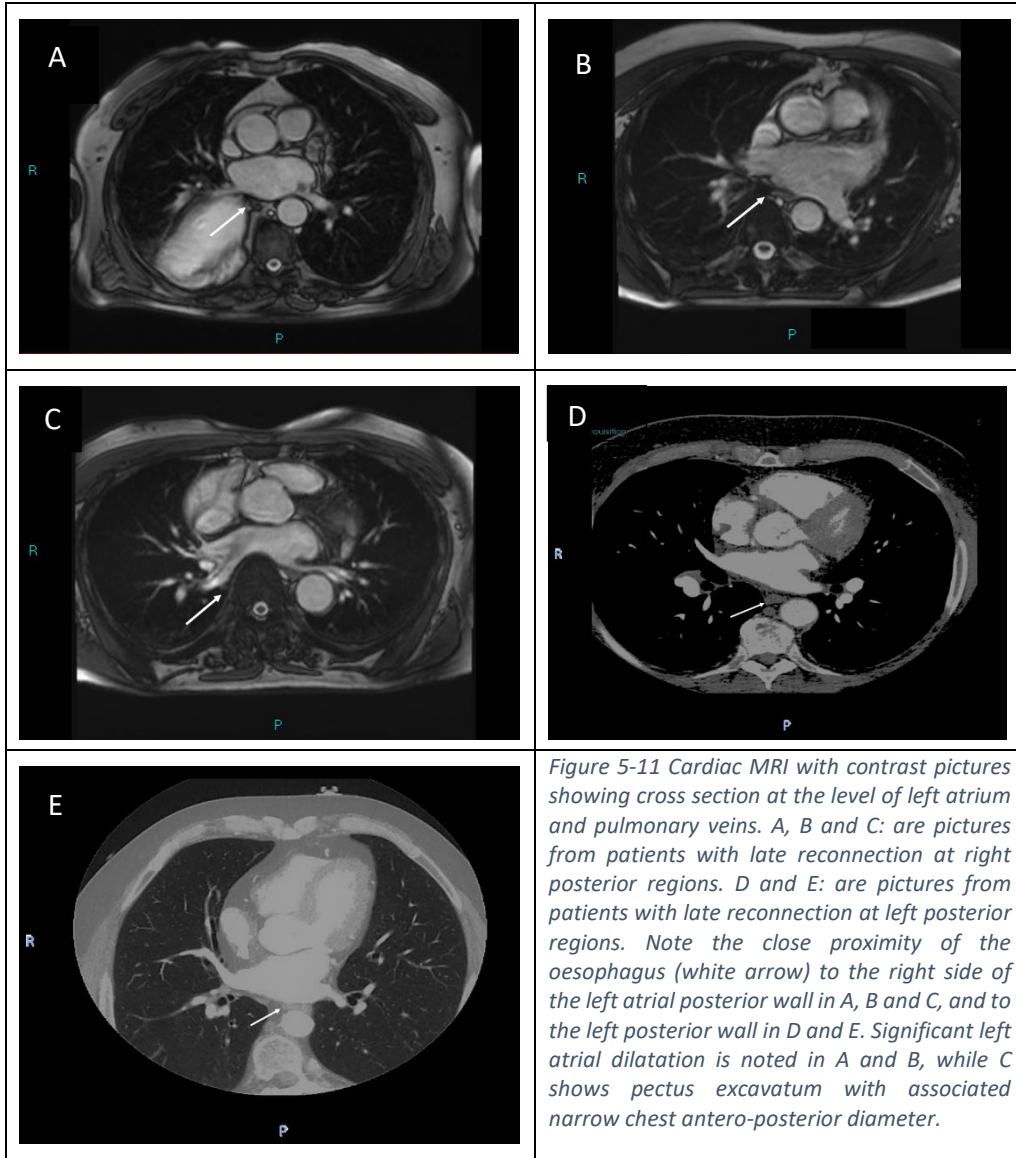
Cardiac MRI with contrast pictures showing cross section at the level of left atrium and pulmonary veins. A, B and C: are pictures from patients with late reconnection at right posterior regions. D and E: are pictures from patients with late reconnection at left posterior regions. Note the close proximity of the oesophagus (white arrow) to the right side of the left atrial posterior wall in A, B and C, and to the left posterior wall in D and E. Significant left atrial dilatation is noted in A and B, while C shows pectus excavatum with associated narrow chest antero-posterior diameter.
